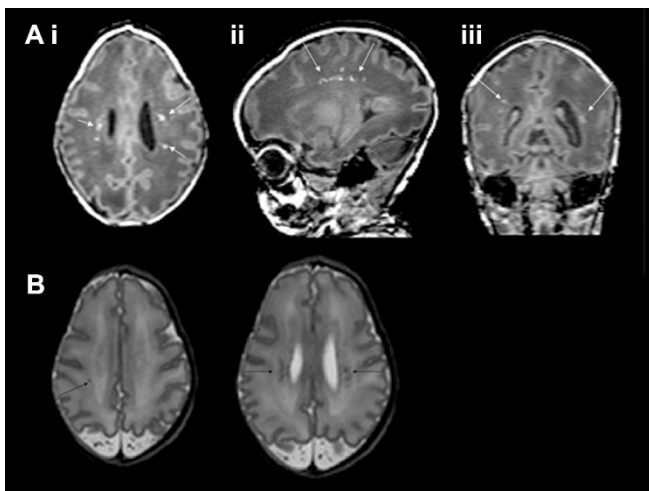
Images of an infant at 33 wk PMA. (A) T1-weighted images in the i) axial, ii) sagittal, and iii) coronal planes and (B) T2-weighted images in the axial plane showing multiple punctate lesions as high signal intensity on T1-weighted imaging and low signal on T2-weighted imaging (arrows).
